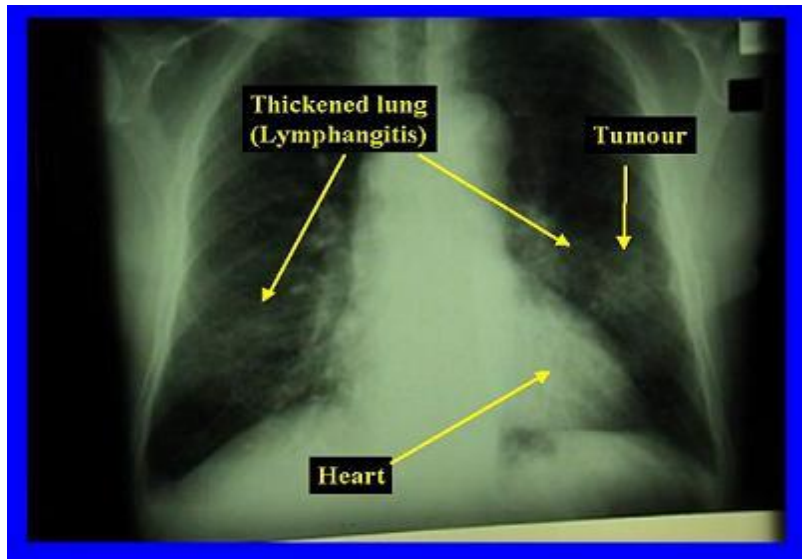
Chest x-ray showing tumour
